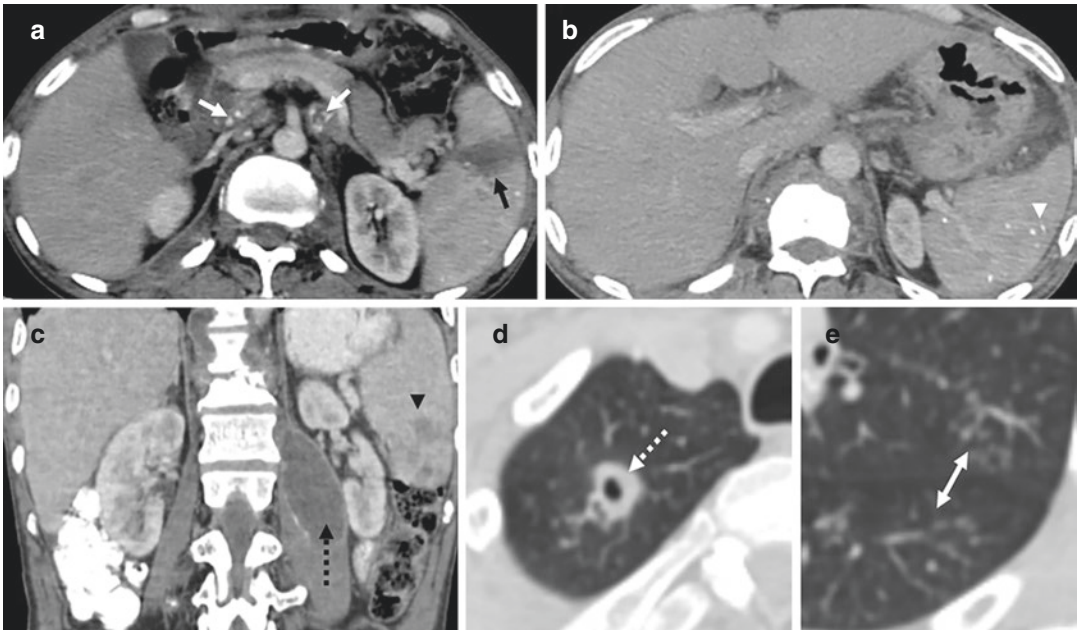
Pulmonary and extrapulmonary tuberculosis. (a–e) Contrast-enhanced CT images show retropancreatic nodes that are (a) enlarged with punctate calcifications (white arrows). In the spleen, there is (a) an infarct (black arrow), (b) punctate calcifications (white arrowhead), and (c) irregular, hypodense nodules (black arrowhead). The
